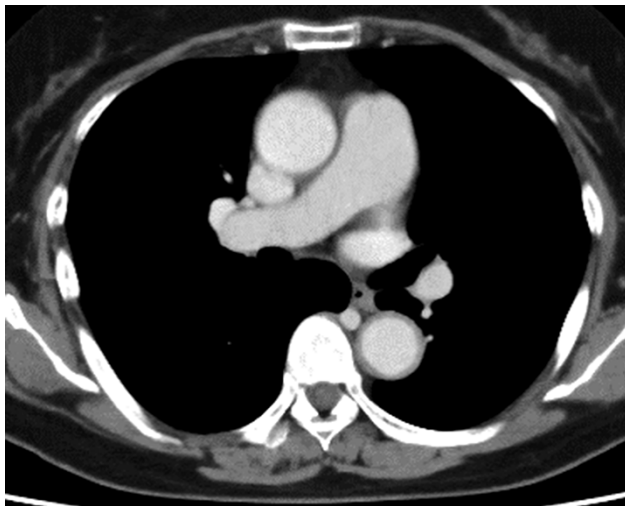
Contrast-enhanced computed tomography demonstrated wall thickening of the thoracic aorta.
